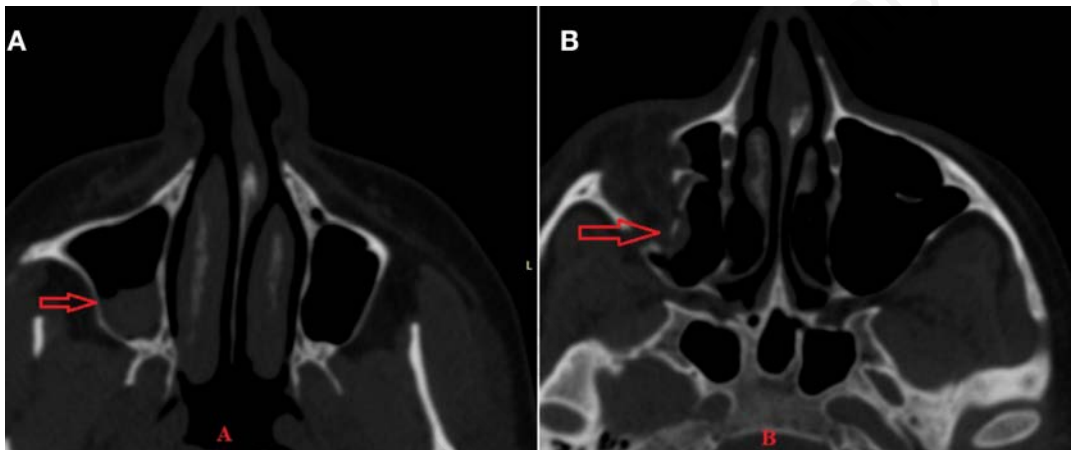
A) Orbital CT images showed hyperdense bleeding in the maxillary sinus; B) Orbital CT images showed a fragmented fracture displaced into the maxillary sinus
